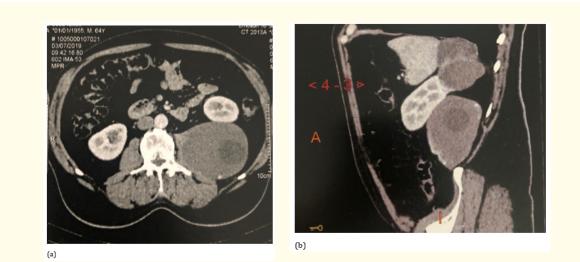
(a) *Transverse CT scan section showing a large hydatid cyst of the psoas attached to the kidney. (b) Sagittal CT scan section showing the double localization of the hydatid cyst (left kidney and psoas).*
